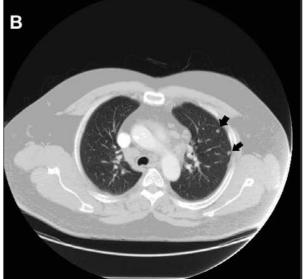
A) Contrast-enhanced CT of the chest demonstrates retrosternal extension of goiter (Arrow); B) lung window showing two non-calcified parenchymal nodules (Arrows); C) multiple enlarged lymph nodes including a precarinal node (Arrow) (Patient 4).
